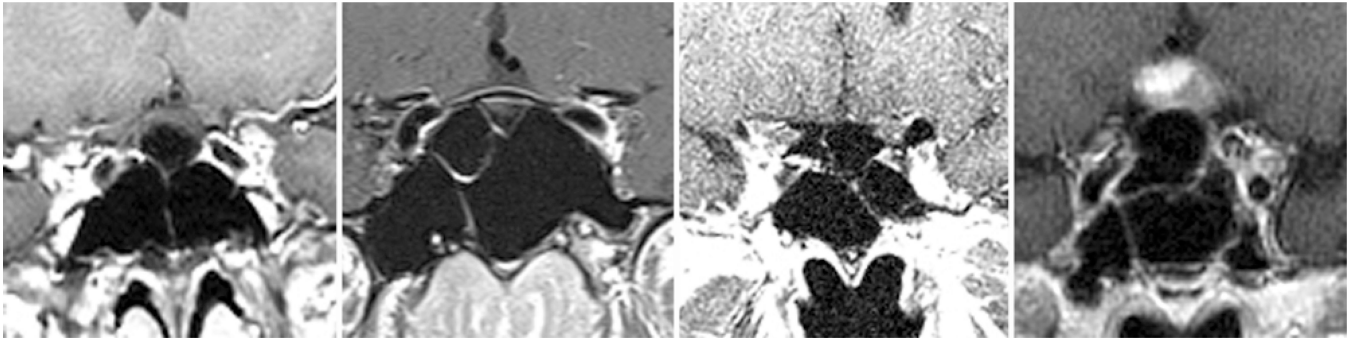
Coronal, postcontrast MR images obtained in patients with sella-based lesions and a complex sphenoid sinus morphology. These patients had more than 2 vertical septations or a combination of horizontal and vertical septa.
